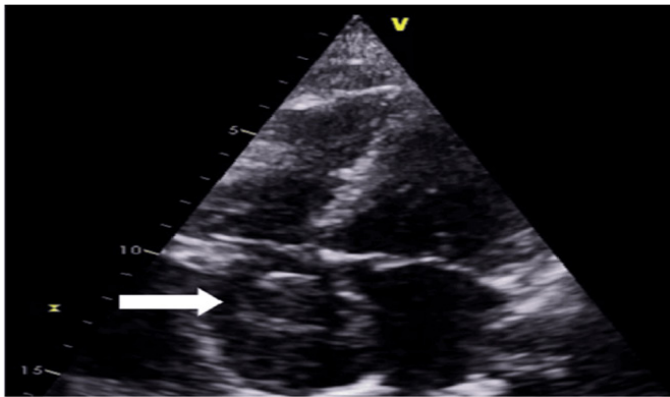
Echocardiogram demonstrating a large echo-dense mass (white arrow) in the right atrium, appearing to almost fill the chamber.
